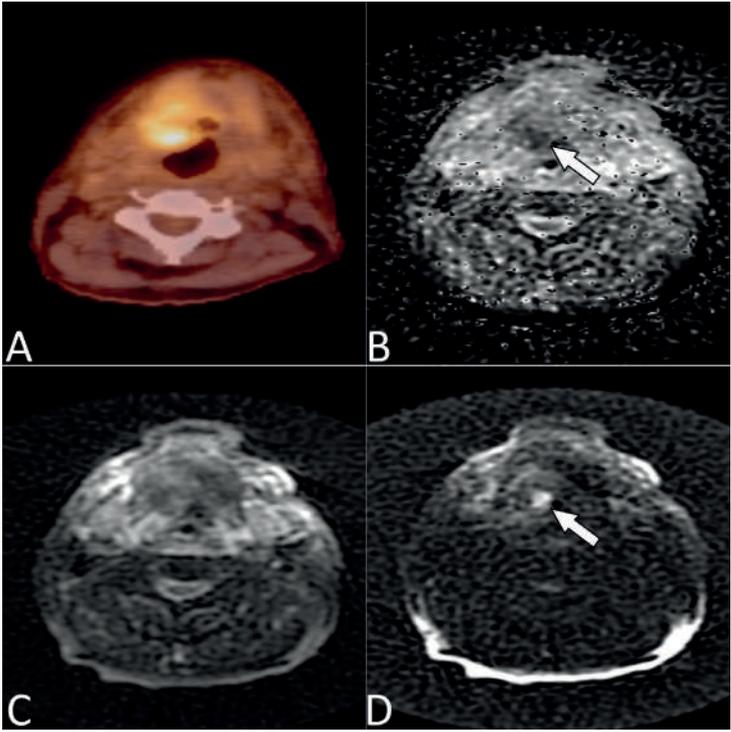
Representative images of a patient with positive DWI findings: Axial images of a 73-year old male 3 months after chemoradiotherapy for a T4N0 oropharyngeal carcinoma (patient 13). On (A) PET-CT there was ¹⁸F-FDG-uptake at the right vallecula which was highly suspicious of malignancy with a SOM score of 4. On the PROPELLER DWI series ((B) ADC map, (C) $b=0$ s/mm² and (D) $b=750$ s/mm²) there was also high risk of malignancy (i.e., there is high signal intensity on (D) $b=1000$ s/mm² and low signal intensity on the (C) ADC map (arrow)) with a SOM score of 4. Biopsy confirmed the presence of malignancy. In this patient both PET-CT and DWI findings are true-positive.
